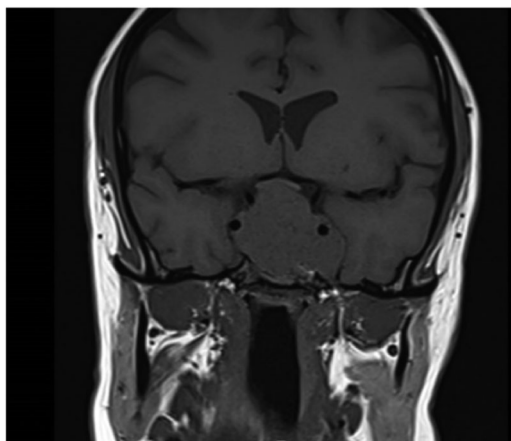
Magnetic resonance imaging pituitary, coronal view, pre-contrast. A $41 \times 41 \times 24$ mm macroadenoma with suprasellar extension, bilateral cavernous sinus involvement and compression of the optic chiasm.
